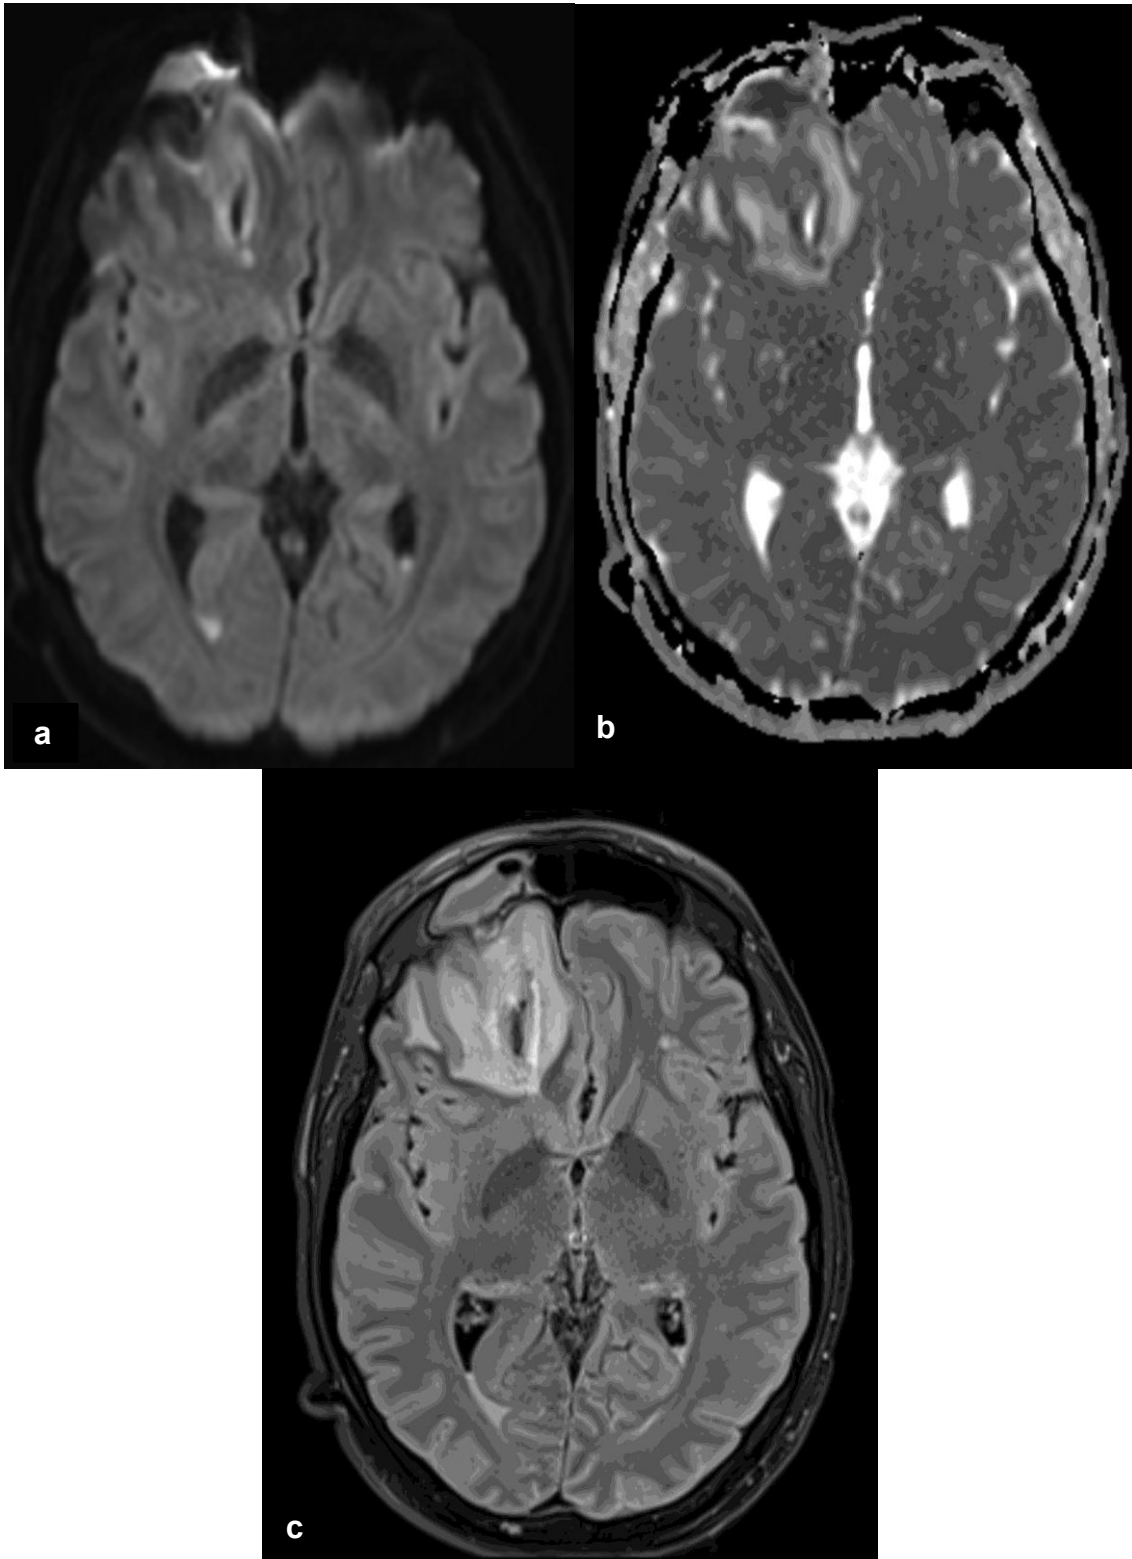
Debris in occipital horns of lateral ventricles showing signs of restricted diffusion (a, b) and the corresponding FLAIR hyperintensity (c). The right frontal lobe abscess and the frontal sinusitis are present (a - c).
